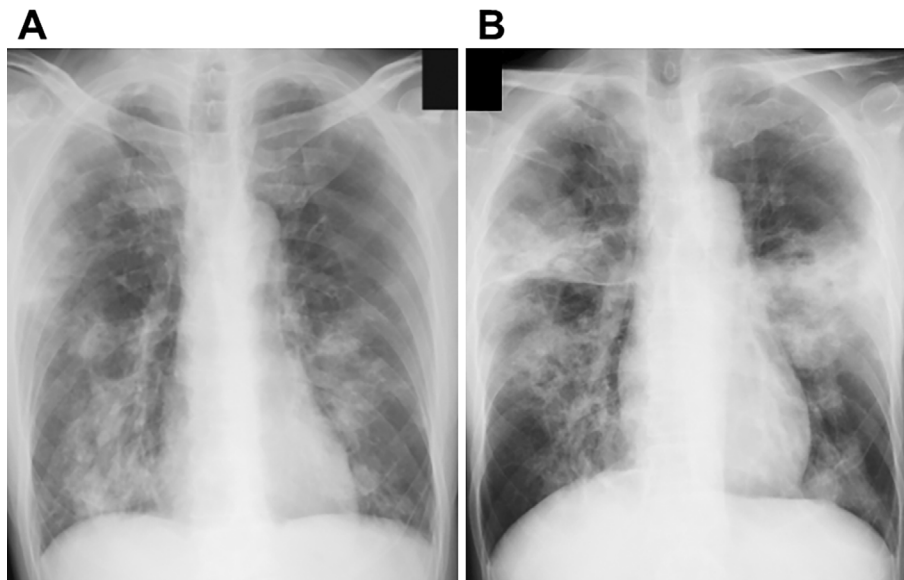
Chest X-ray films obtained in the former hospital (A) and on admission to our hospital in February 2017 (B). Bilateral infiltrates, mainly in middle field, progressed rapidly within about one week.
